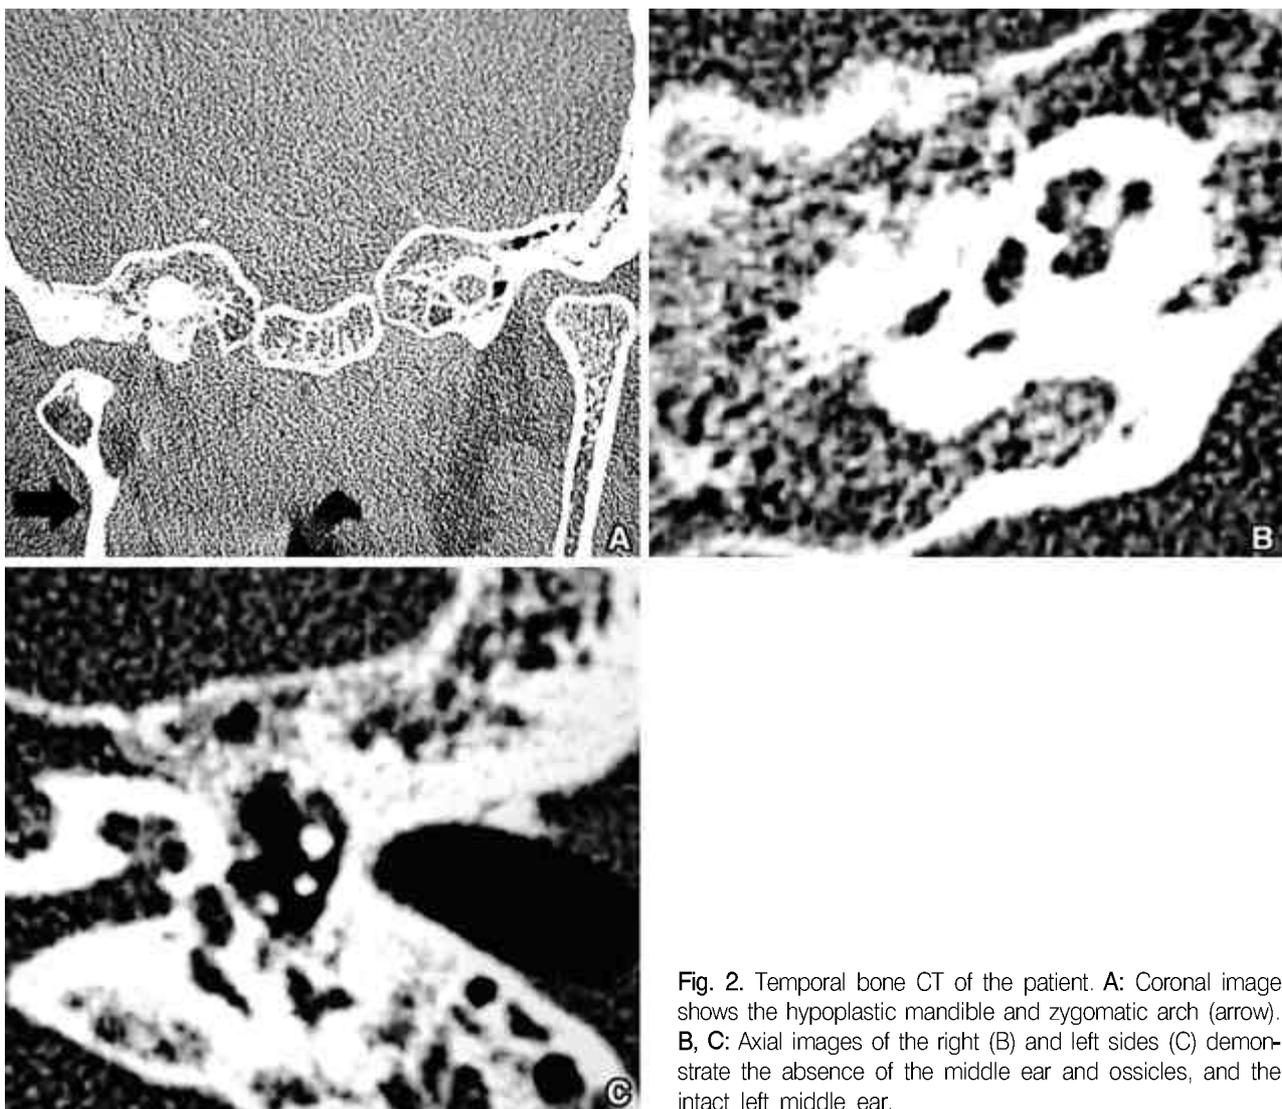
Temporal bone CT of the patient. A: Coronal image shows the hypoplastic mandible and zygomatic arch (arrow). B, C: Axial images of the right (B) and left sides (C) demonstrate the absence of the middle ear and ossicles, and the intact left middle ear.
